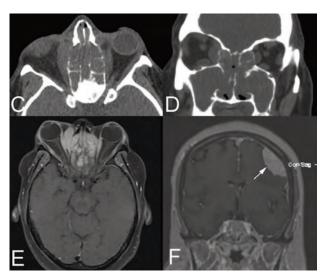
C and D: Axial and coronal CT, soft tissue window, demonstrated marked sinus infiltration with bone erosion and soft infiltration into the medial orbits, worse on the right.
